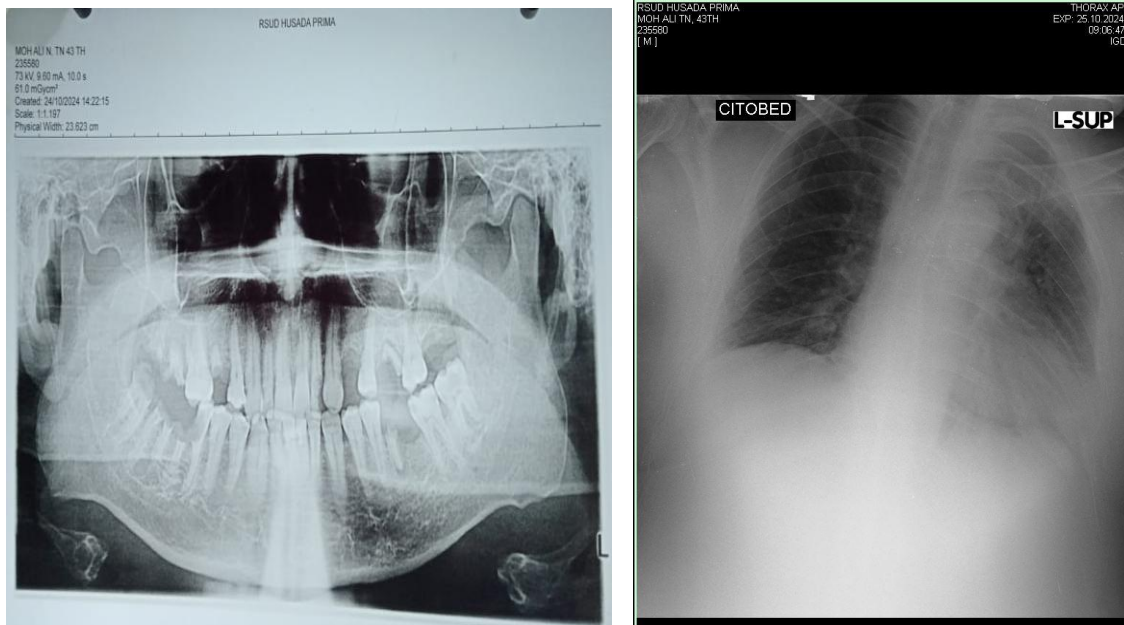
Left: Panoramic dental X-ray (OPG) revealed extensive caries and periapical pathology involving the lower second and third molars, supporting an odontogenic source of infection. Figure 2 Right: Chest radiograph showed bilateral infiltrates consistent with active pulmonary tuberculosis, particularly in the upper lobes, correlating with the patient's TB history
